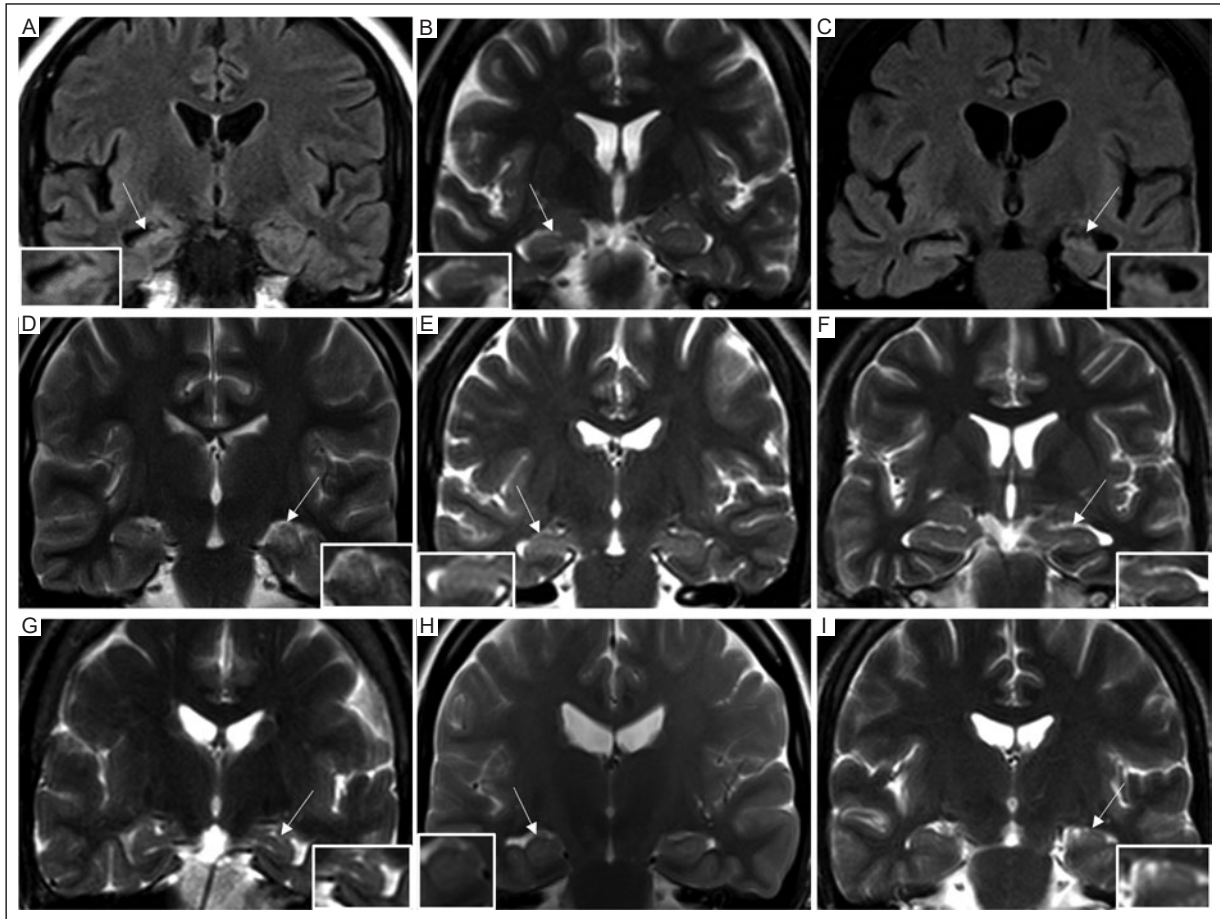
Examples of typical findings on preoperative structural MRI in patients with refractory TLE showing volume and signal abnormalities in the hippocampus. Magnified views are shown. A: coronal FLAIR view of a 38-year-old woman with atrophy and increased signal intensity in the right hippocampus (arrow). B: coronal T2-weighted view of a 36-year-old woman with atrophy and increased signal intensity in the right hippocampus (arrow). C: coronal FLAIR view of a 43-year-old woman with atrophy and increased signal intensity in the left hippocampus (arrow). D: coronal T2-weighted view of a 33-year-old man with atrophy and increased signal intensity in the left hippocampus (arrow). E: coronal T2-weighted view of a 27-year-old woman with normal volume and increased signal intensity of the right hippocampus (arrow). F: coronal T2-weighted view of a 32-year-old man with atrophy and normal signal intensity of the left hippocampus (arrow). G: coronal T2-weighted view of a 35-year-old woman with atrophy and normal signal intensity in the left hippocampus (arrow). H: coronal T2-weighted view of a 21-year-old woman with atrophy and normal signal intensity in the right hippocampus (arrow). I: coronal T2-weighted view of a 35-year-old man with atrophy and normal signal intensity in the left hippocampus (arrow).
